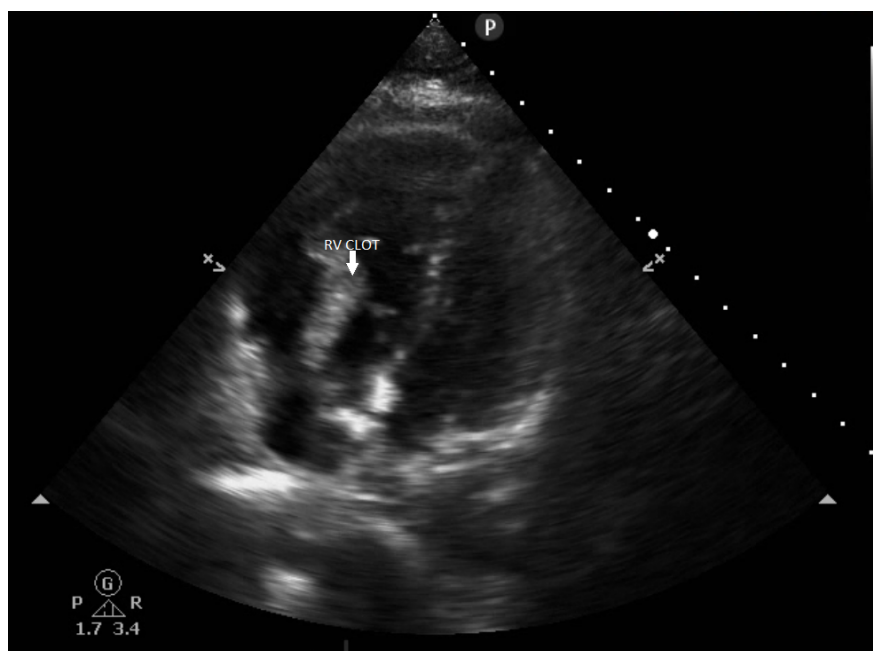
Apical 4 chamber view showing thrombus in transit protruding into right ventricular cavity
